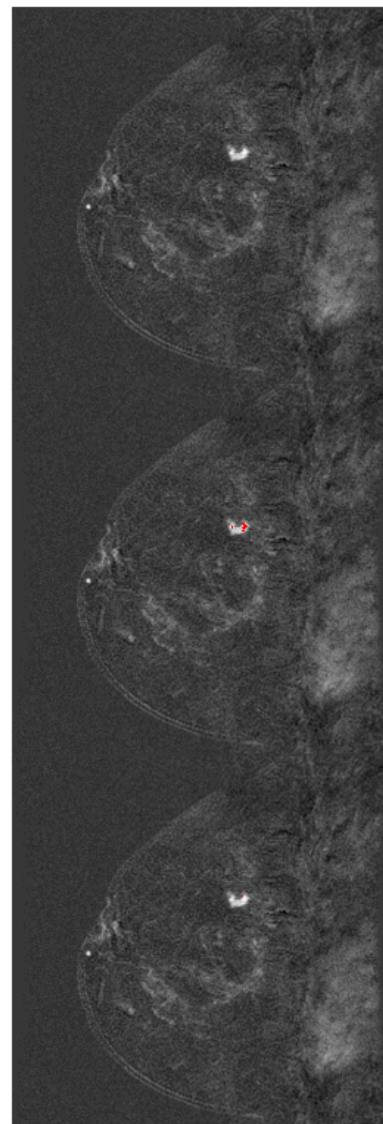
A breast MRI examination exhibiting a malignant lesion (top pane), the computer-aided diagnosis results of a robust support vector machine ($\gamma = e^{-2}$, middle pane) and computer-aided diagnosis results of an overfitted support vector machine ($\gamma = e^{12}$, bottom pane). Both classifiers were trained on the same data and have the same bias setting.
